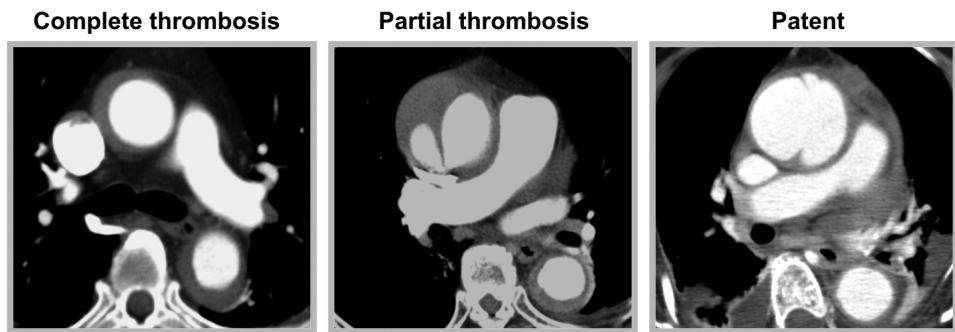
Enhanced computed tomography images, which show complete thrombosis, partial thrombosis, and patent false lumen
